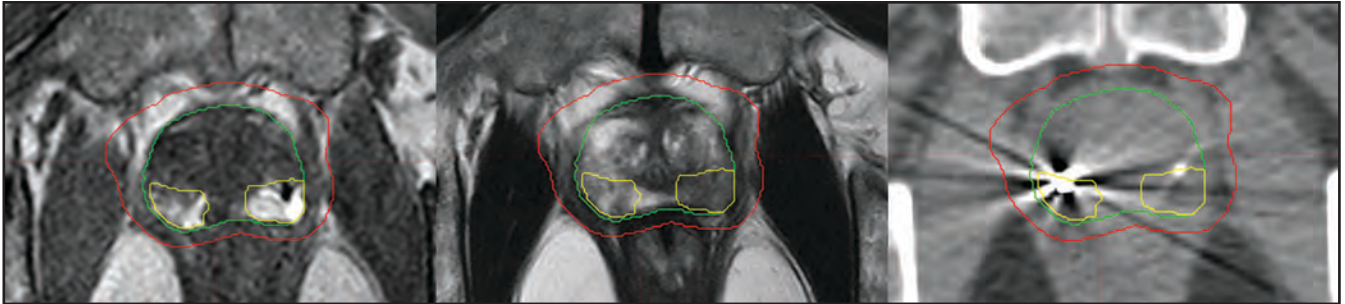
Dominant intraprostatic lesion (DIL) visualization comparisons on MRI THRIVE, T2 and CT axial slice, DIL (yellow), prostate (green), planning target volume (PTV) (red).
